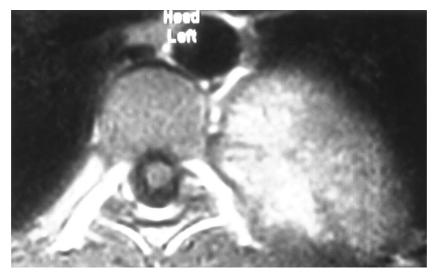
T1-Weighted axial MR image; the lesion is heterogeneous hyper-isointense relative to muscle.
